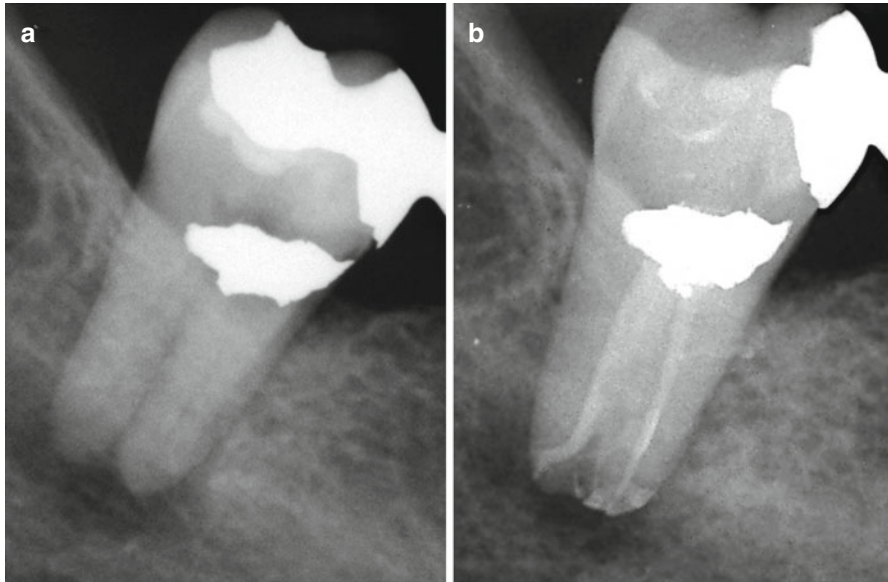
Periapical radiograph of a right mandibular second molar with associated apical pathosis (a) and the post-endodontic periapical radiograph with obturation material demonstrating the complex nature of the root canal system (b)
